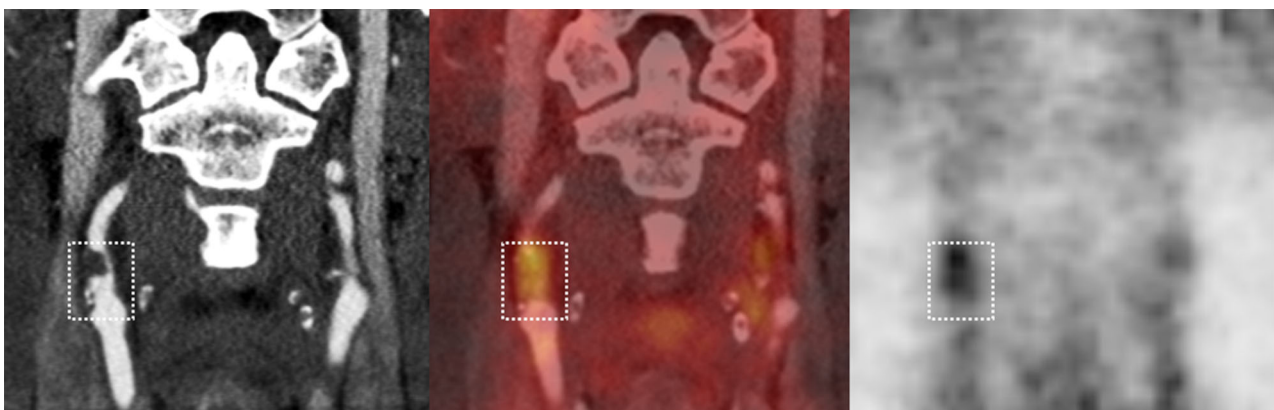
¹⁸F-FDG PET/CT of stenotic plaque in the right internal carotid artery. From left to right: CT angiography, co-registered PET/CT, and ¹⁸F-FDG PET. The white box shows the plaque extension craniocaudally with lumen contrast-filling defect and vessel wall thickening on CT angiography (left image).
